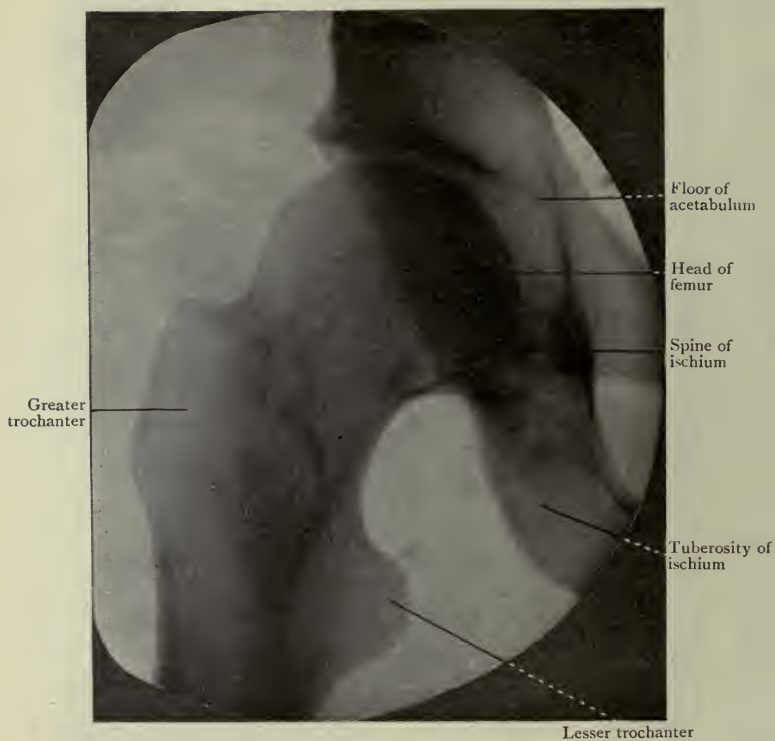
Radiograph of the Hip Joint of an adult.
